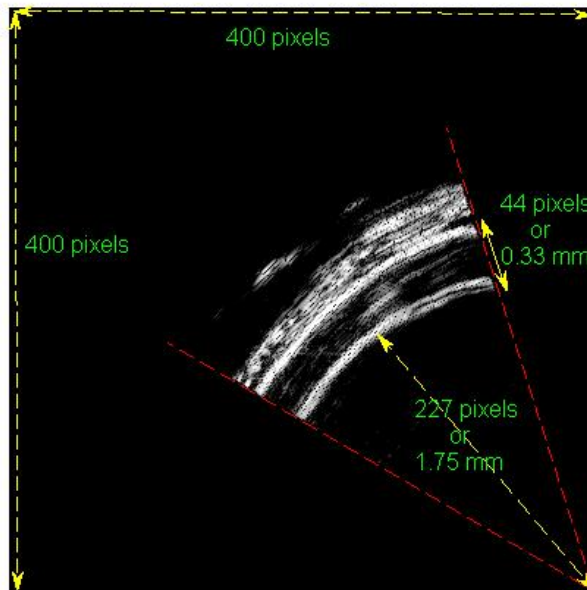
Ultrasound image of the coronary vessel wall at 60 mmHg
